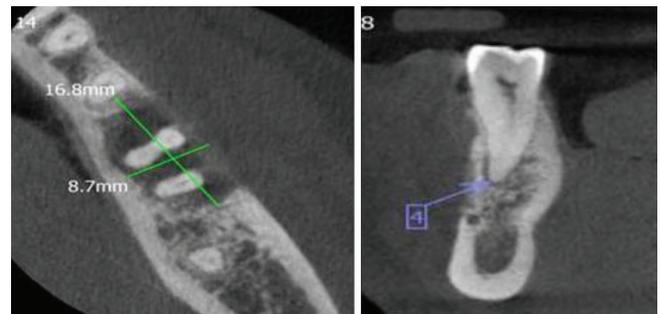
Axial CBCT showing extension of bone involvement; Figure-5: widening of periodontal ligament space with adjacent tooth
